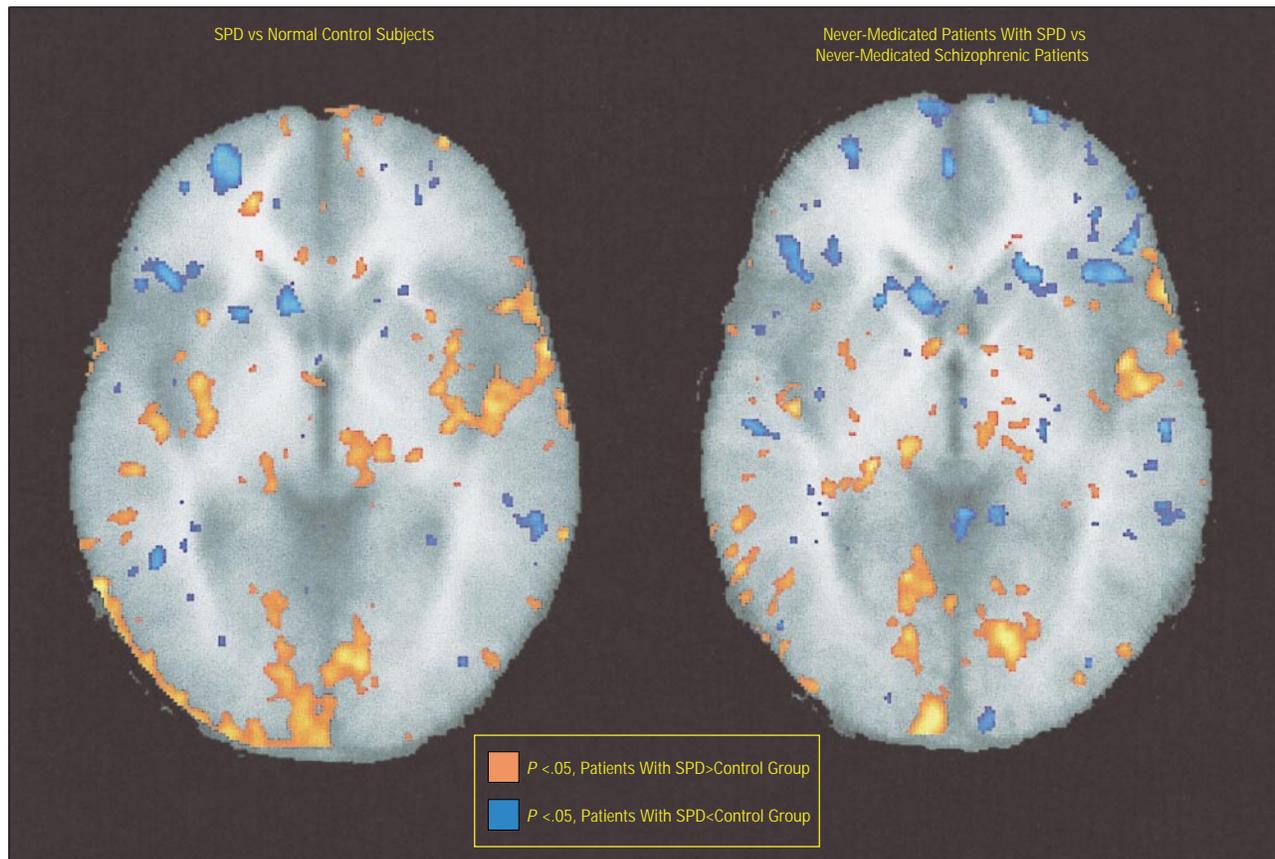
Significance probability maps contrasting patients with schizotypal personality disorder (SPD) who never received medication (ie, the never-medicated patients) with normal control subjects and never-medicated schizophrenic patients. *t* Tests comparing relative metabolic rate are presented on the background of the coregistered average standardized magnetic resonance image ($z = -4^21$). Note that the patients with SPD show the same caudate decrease and putamen increases observed with individual putamen templates (Figure 2) and multivariate analysis of variance on the entire striatal area in Table 1, indicating agreement between the 3 statistical methods. Left side of the brain is on the right side of the image.
